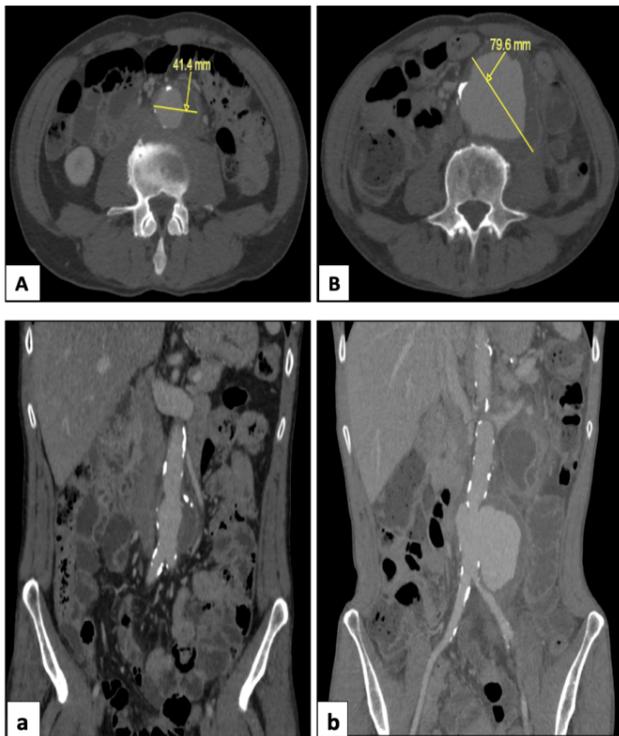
Angio-computed tomography scans visualizing the augmentation of IRA diameter within 1 month (A/a before; B/b after).
